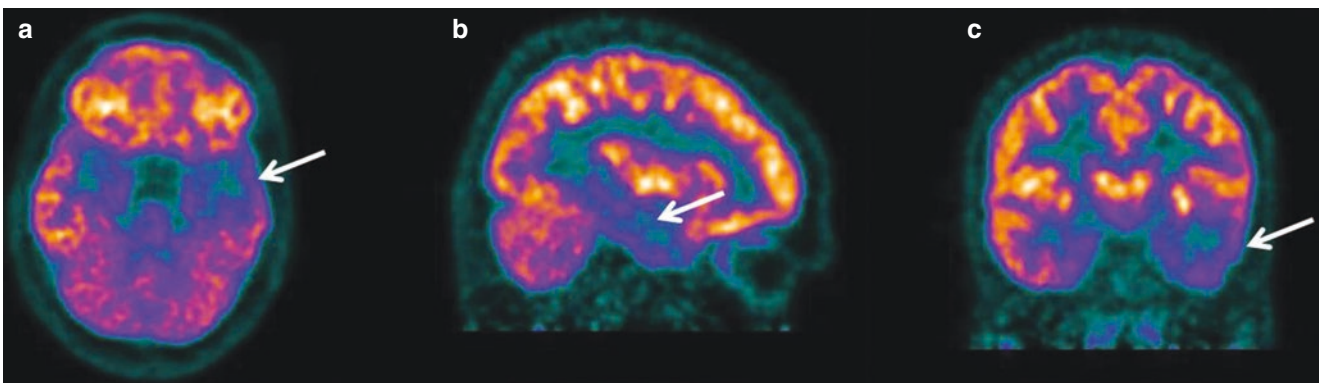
Interictal ^{18}F -FDG PET/CT brain scan of a 22-year-old male patient with medically refractory epilepsy. Transverse (a), sagittal (b) and coronal (c) views of the brain showing diffuse hypometabolism at the left temporal lobe (*arrow*)
